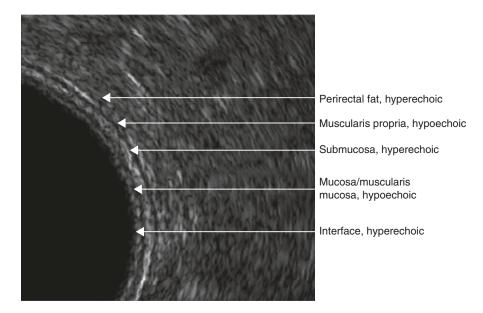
Endorectal ultrasound, layers of the rectal wall and the mesorectum
